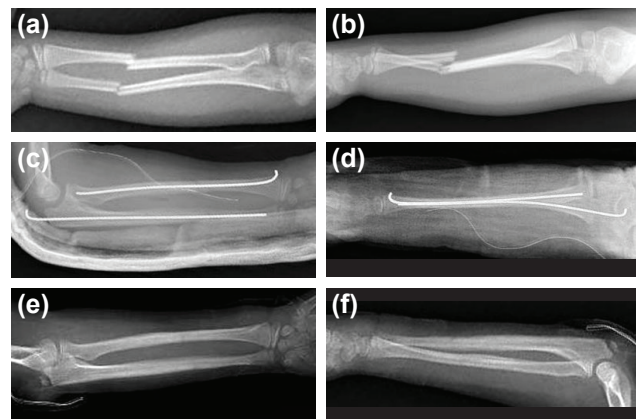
(a) Anteroposterior and (b) lateral radiographs showing displaced and angulated diaphyseal both-bone right forearm fractures in an 8-year-old girl. (c) Early anteroposterior and (d) lateral radiographs showing IM K-wire fixation of ulna and radial fractures in the same patient. (e) Anteroposterior and (f) lateral radiographs of the forearm after hardware removal.
